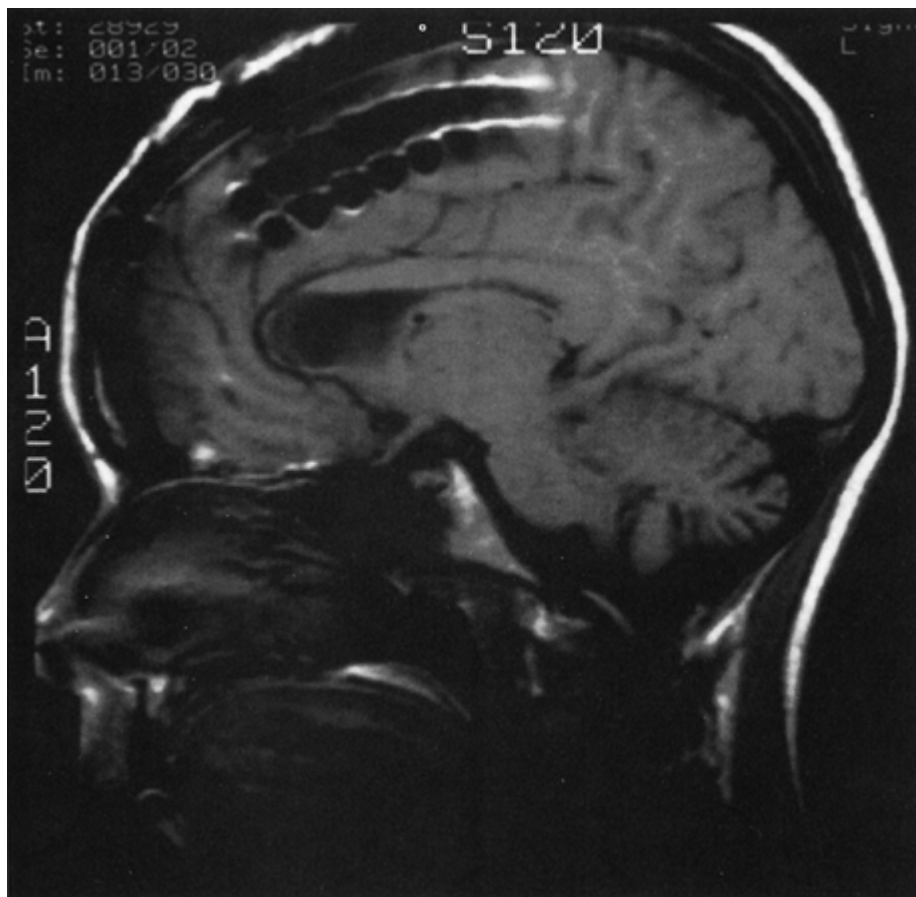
Midline sagittal magnetic resonance imaging (MRI) view of interhemispheric placement of subdural strips.
